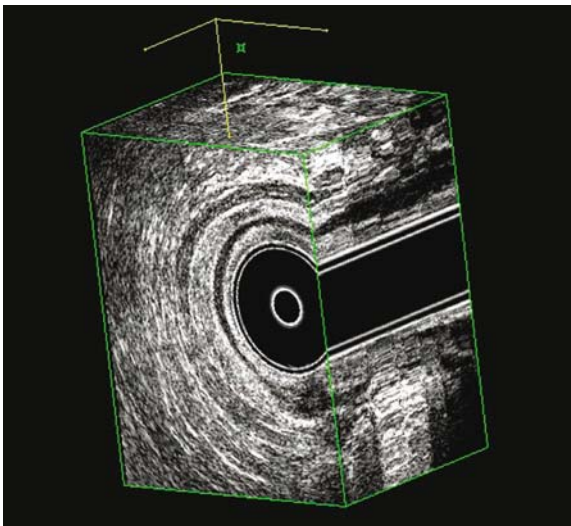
Anal endosonography showing an obvious large extension (arrows). The surrounding anatomy is distorted, and it is difficult to be sure whether the extension is infralevator, supralevator, or includes elements of both
